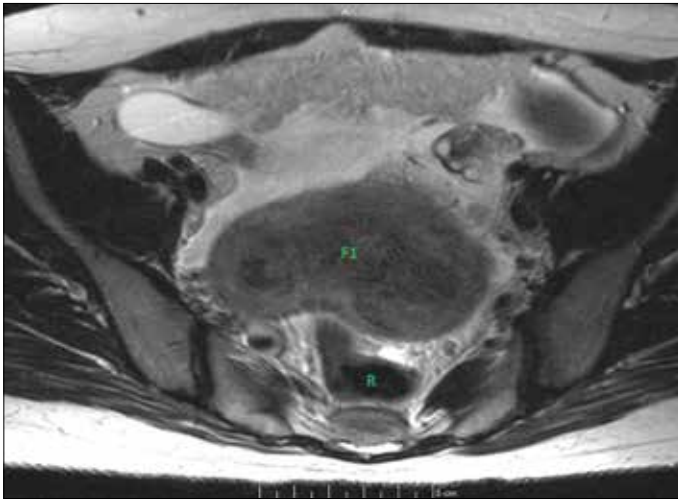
MRI showing a lobulated pedunculated fibroid 9×6×7 cm (F1) arising from the rectum (R)
